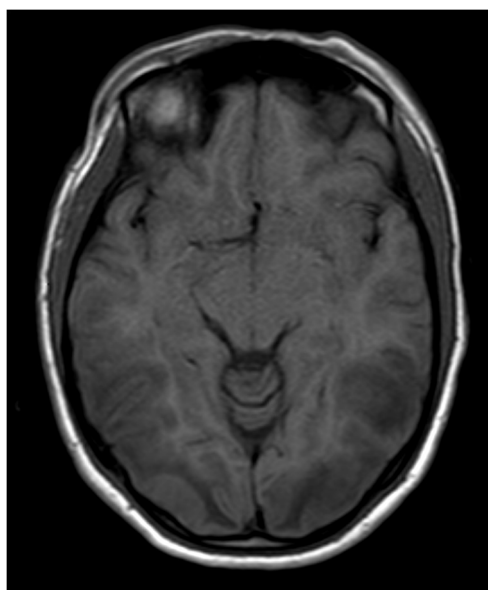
MRI BRAIN T1 AXIAL
